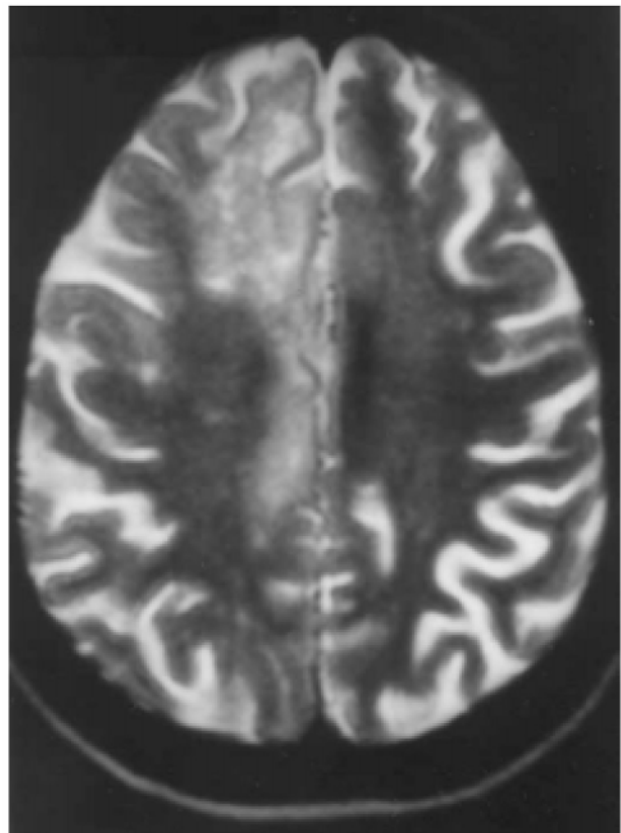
MRI of case 3 showing hyperintense white matter lesions in superior longitudinal fasciculus on T2-weighted images.
